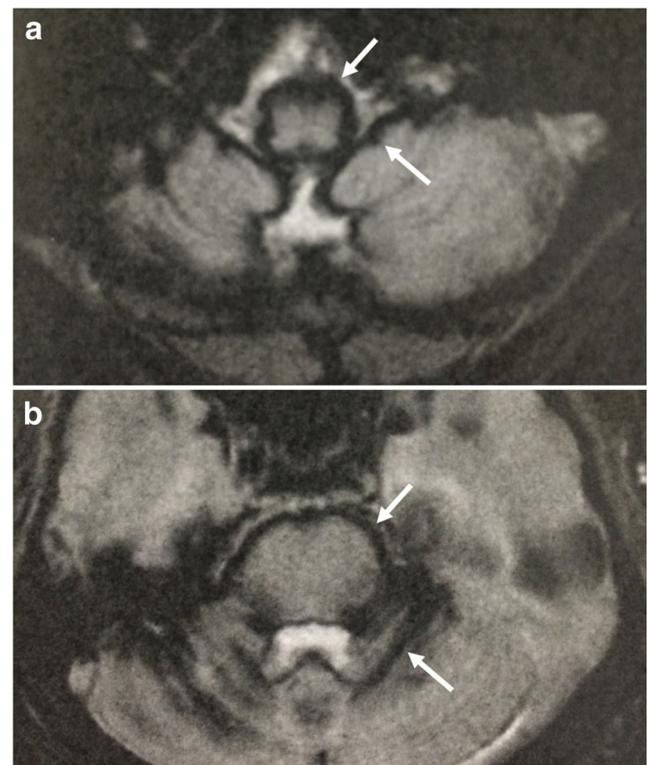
Axial T2W*-weighted brain MRI of a patient with superficial siderosis shows hypointense rim in the leptomeninges around the cerebellum and brainstem, characterizing hemosiderin deposition
